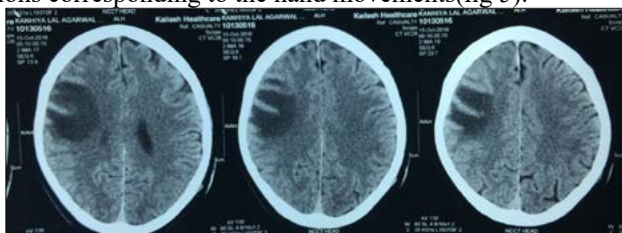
Contrast enhanced CT scan Head 14 months after head injury
